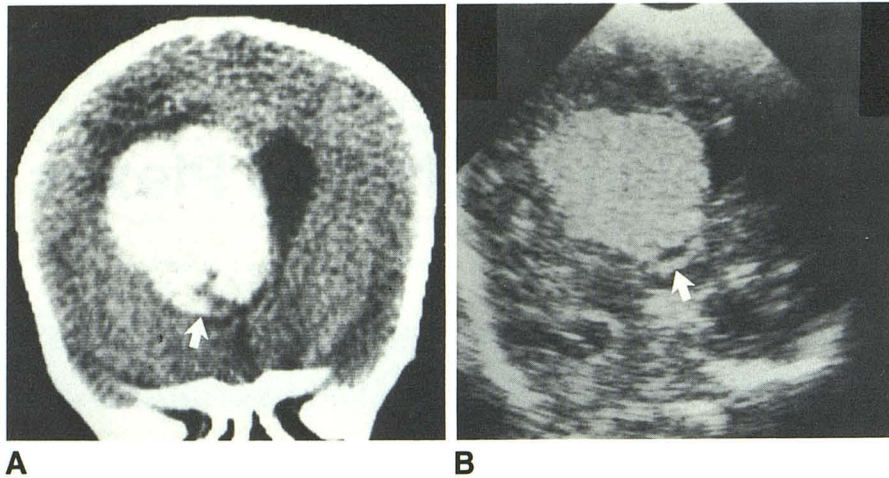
A, Direct coronal contrast CT scan shows right intraventricular radiodense mass with an inferior finger of tumor (arrow) extending through foramen of Monro.
